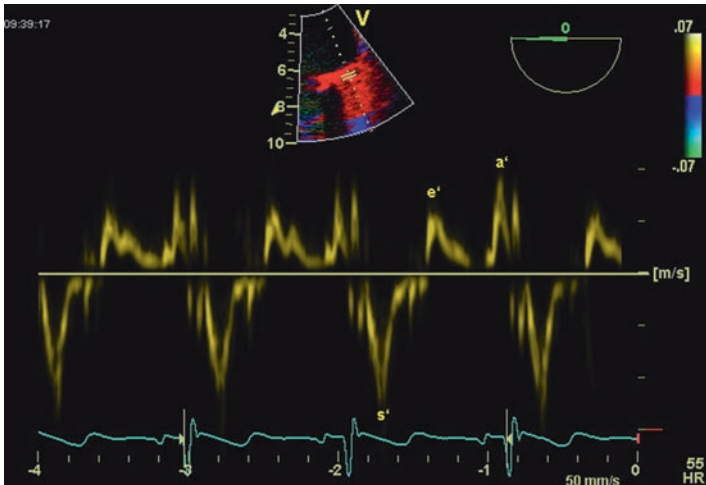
Pulse wave Doppler tissue imaging (DtI) recording from the lateral mitral annulus recorded from the mid esophageal 4 chambers view demonstrating early diastolic (e'), late diastolic (a') and systolic (s') velocities.
